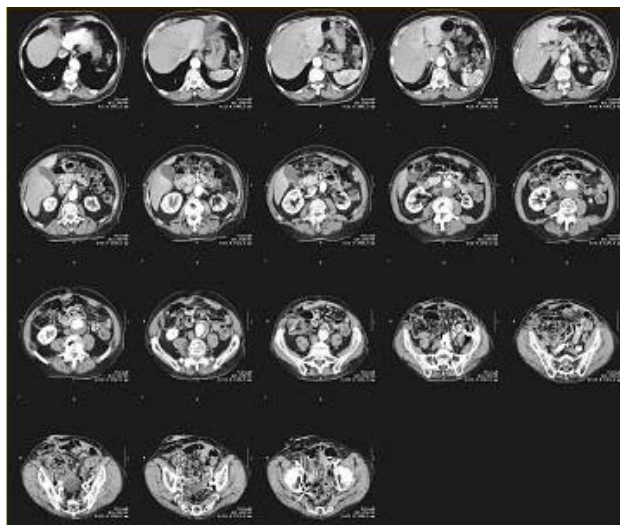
CT scan images of the abdominal trunk of a patient with an AAA.
